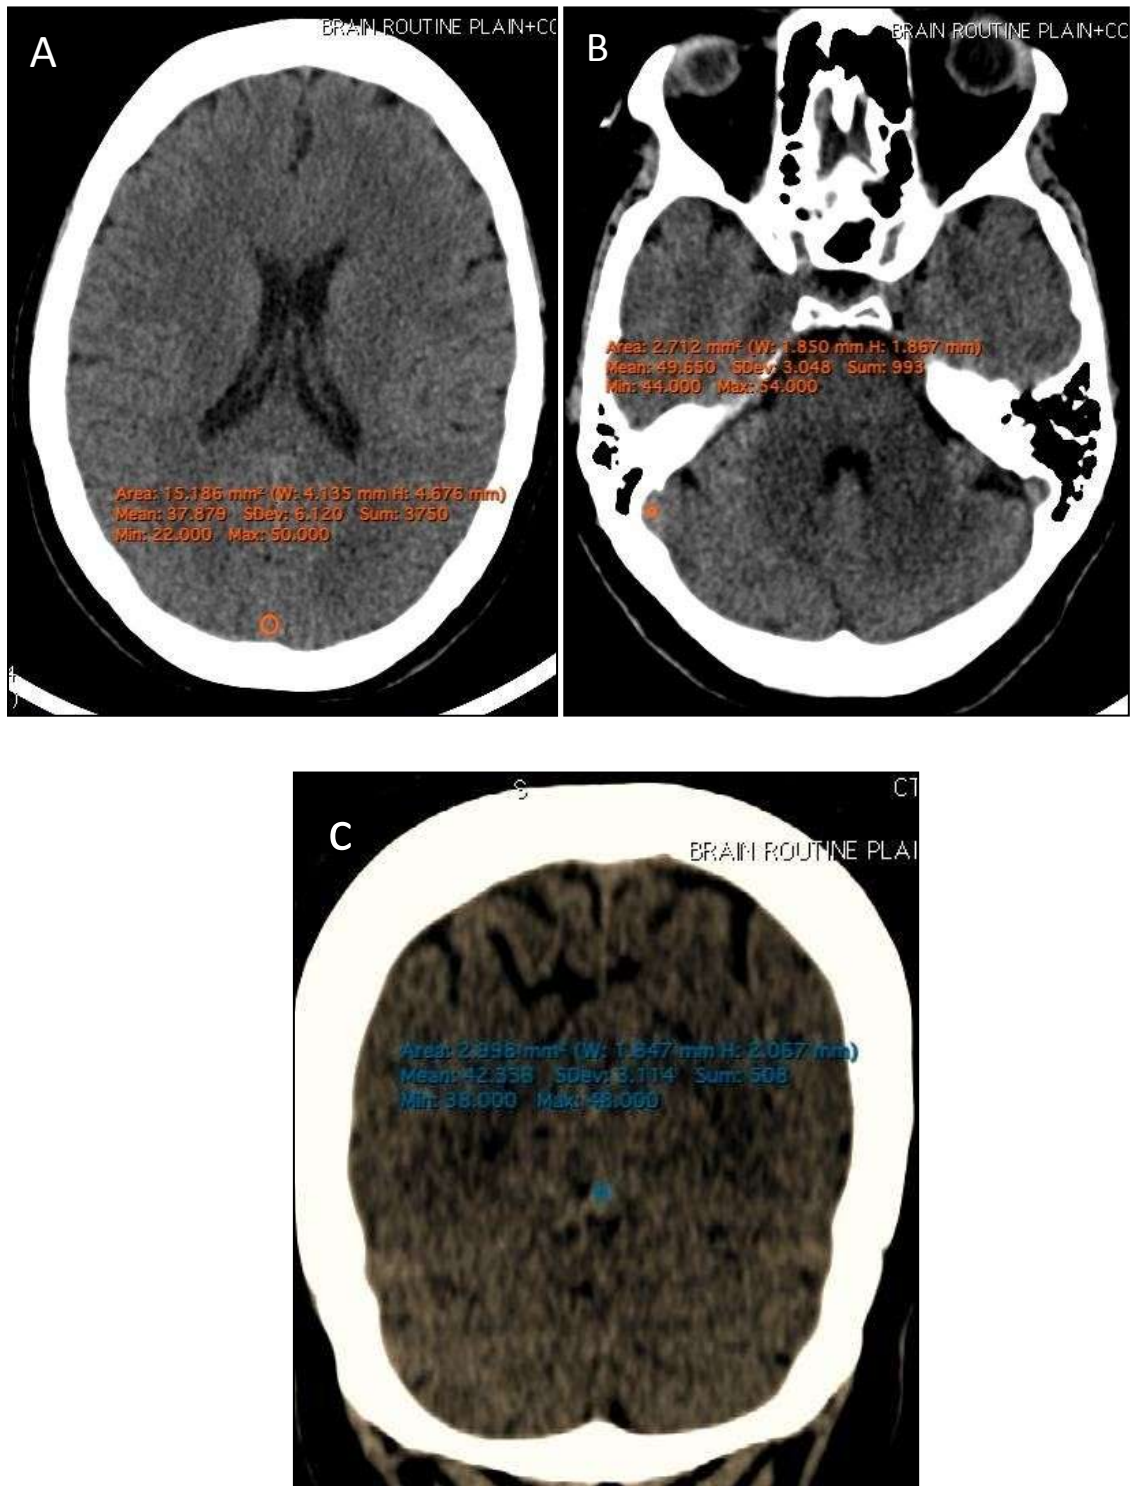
A, B, C: Axial and coronal sections of unenhanced CT scan showing a method of measurement of HU using ROI's in SSS, transverse sinus and torcula respectively
